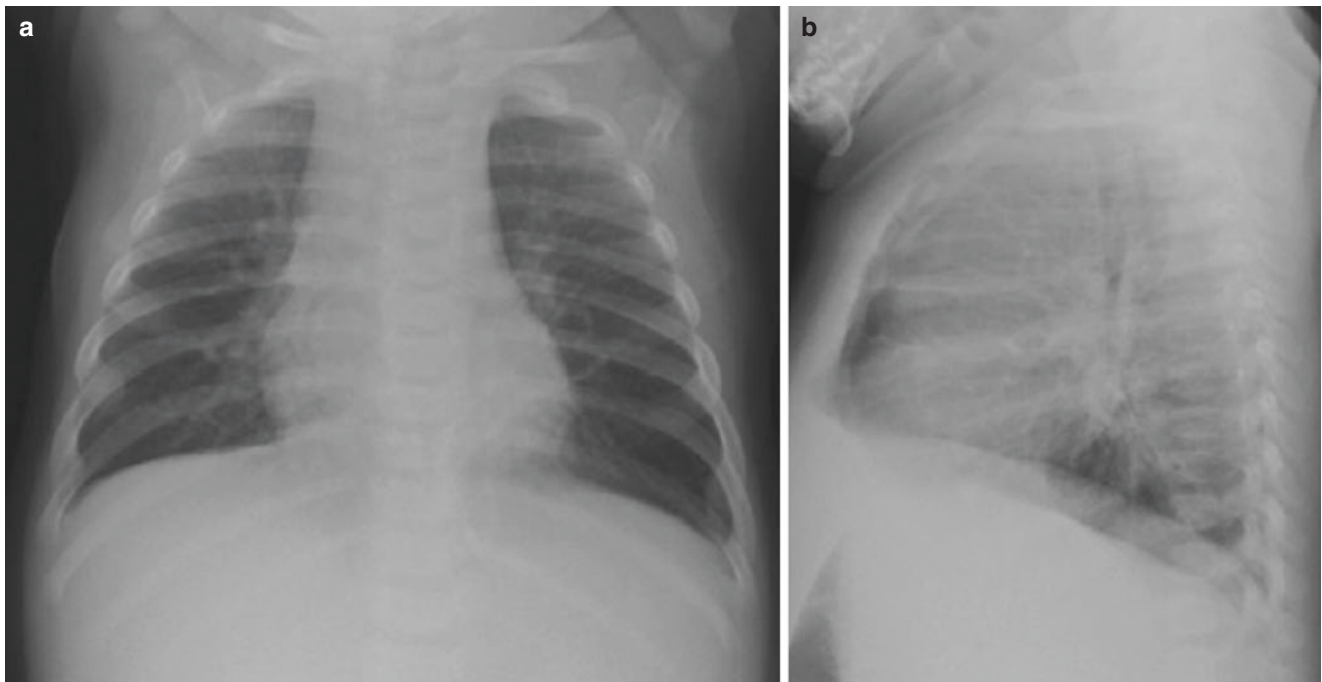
A 3-month-old boy with RSV-positive bronchiolitis who presented with respiratory distress. Frontal (a) and lateral (b) chest radiographs show the flattening of the diaphragm which is the most reliable
